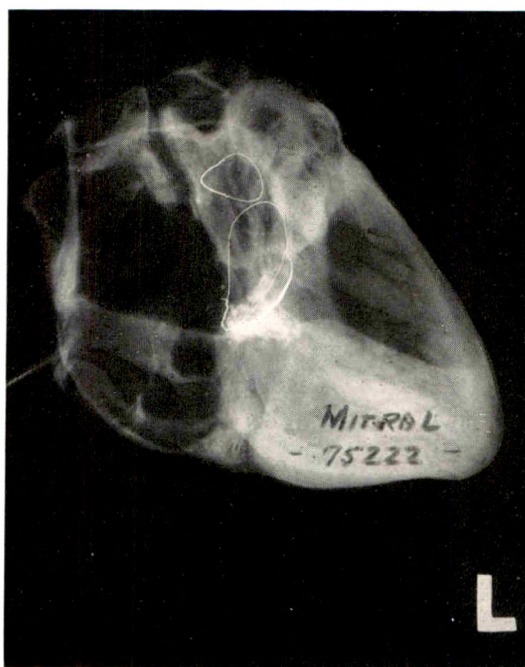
Roentgenogram of heart post mortem. Fine wires at attachments of valves, lower-mitral, upper-aortic. Metal strip in narrow orifice of mitral valve (Case XIX).
